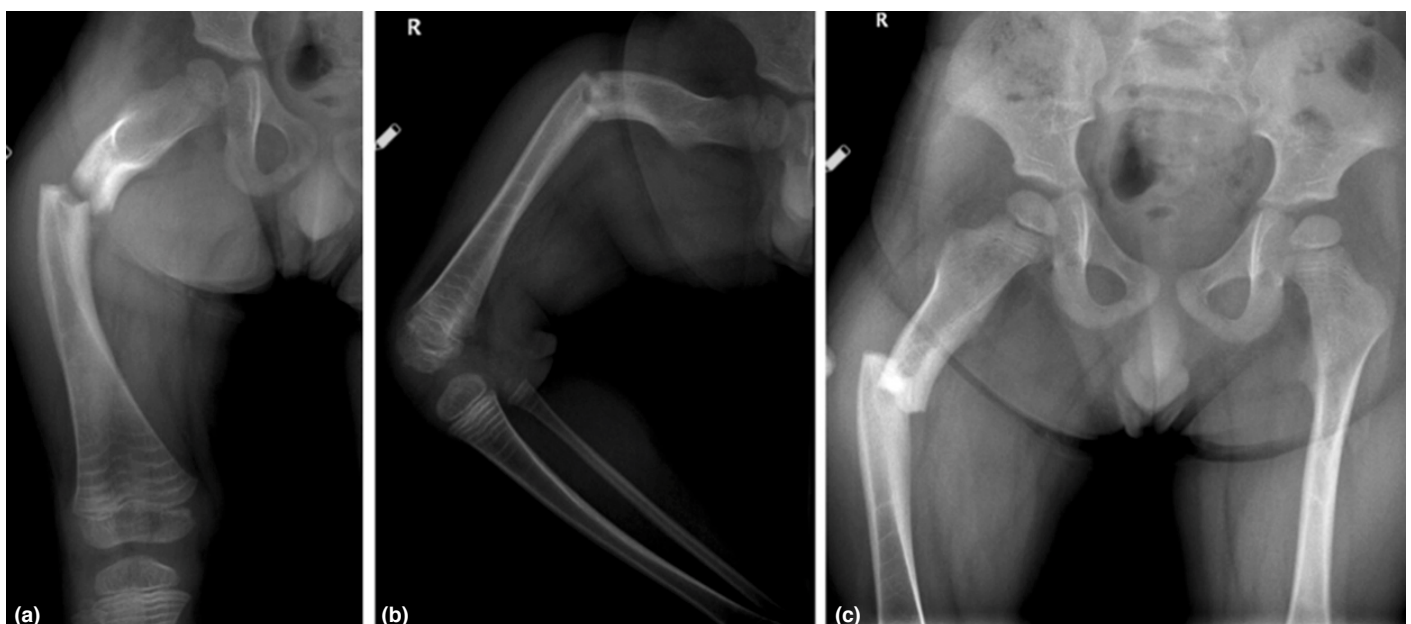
X-ray images of the patient at the time of arrival to our hospital. (a) Right femur ap view. (b) Right femur lateral view. (c) Pelvis ap view.
